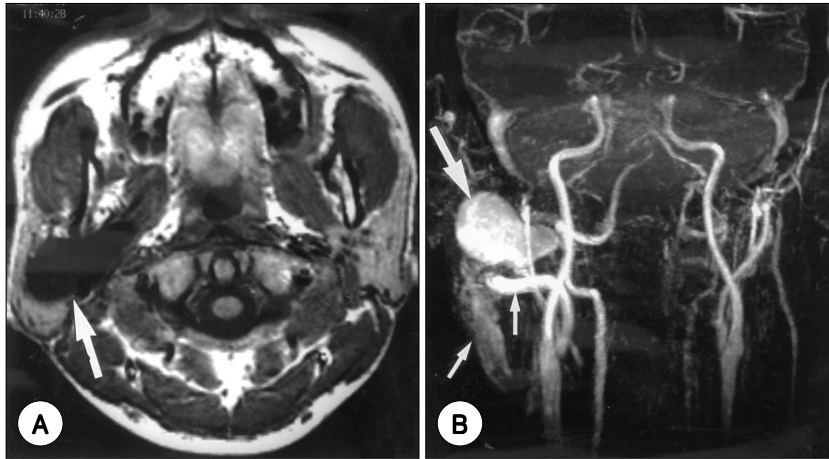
A : T1-weighted image shows a large aneurysmal sac in right deep parotid area (arrow). B : MR angiogram shows the same aneurysmal sac (thick arrow), an enlarged external carotid arterial branch (Rt. small arrow) and an enlarged draining vein (Lt. small arrow).
